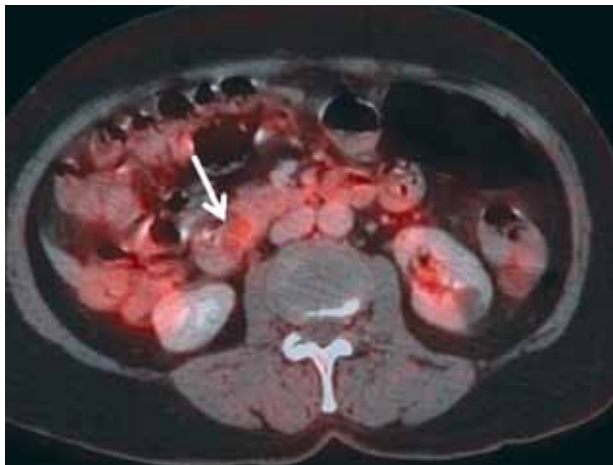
Primary ampullary tumor is noted with increased uptake (SUV max 4.1)
